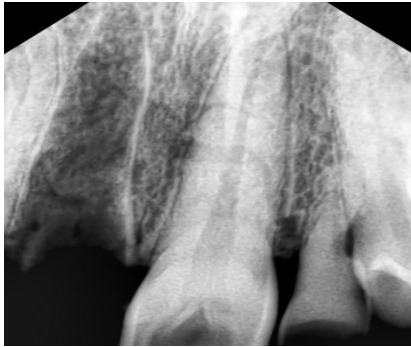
Radiograph of 11 and 21 teeth region
